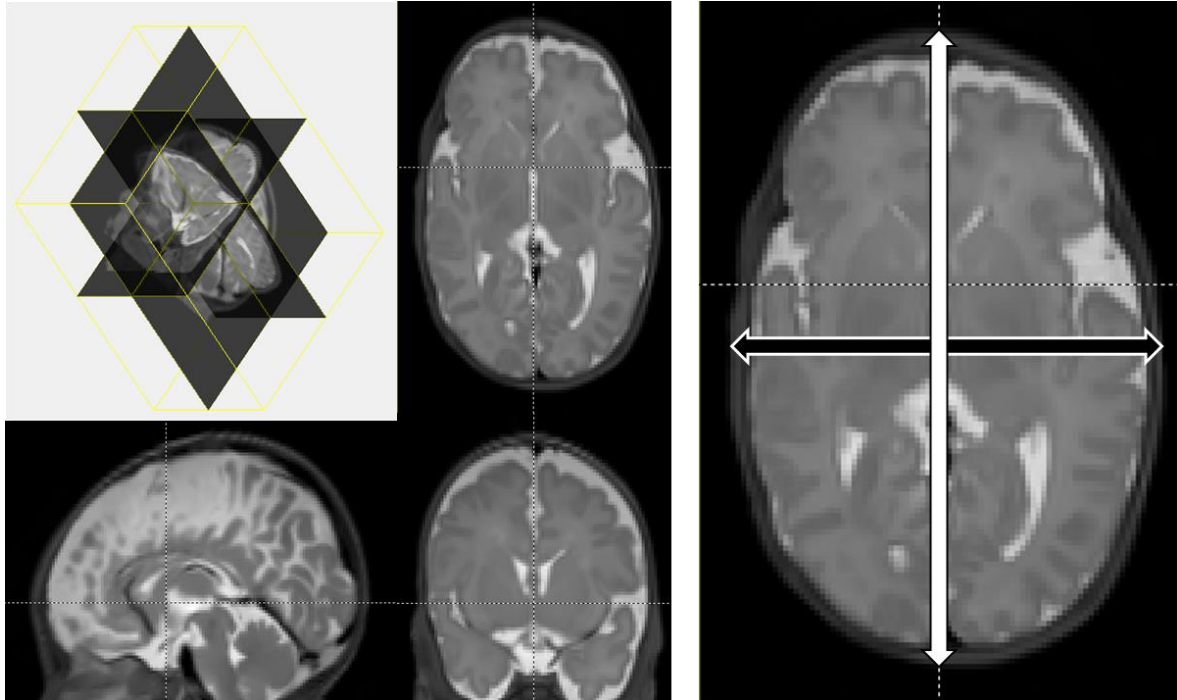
Evaluation of the degree of dolichocephalic deformation using the minor diameter to major diameter ratio (MRI-based cranial index).
